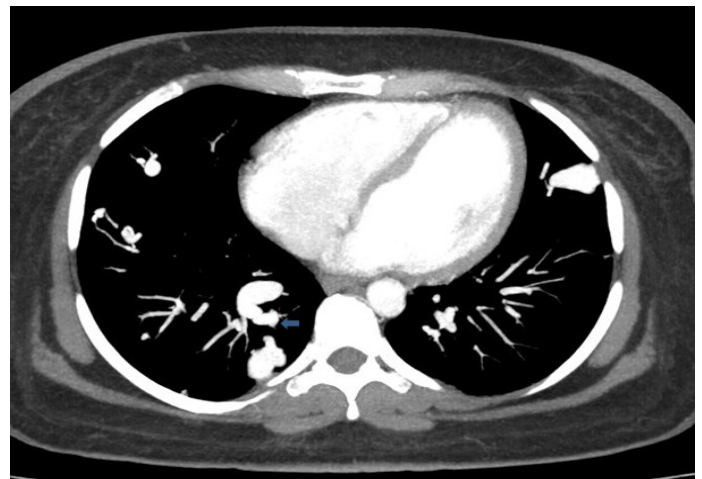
Axial CT scan with contrast medium showing multiple aneurysmal sacs in both lung fields.
